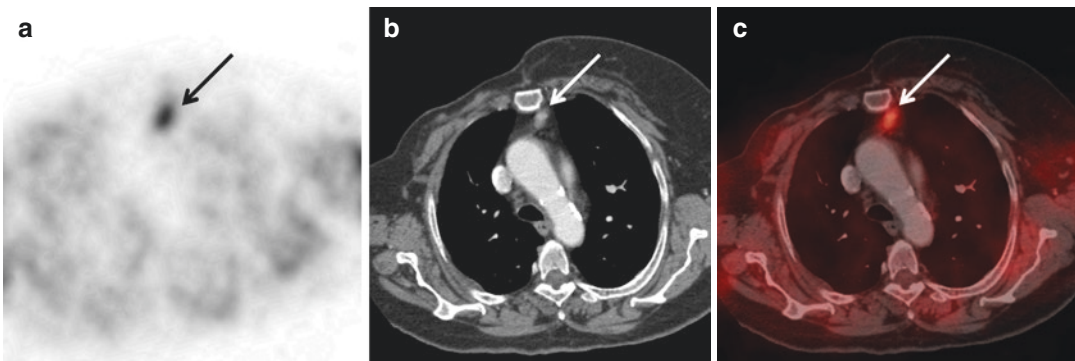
Thorax CT images. A soft tissue mass (arrow)  $15 \times 9.5$  mm. was seen in anterior mediastinum between sternum and arcus aorta
